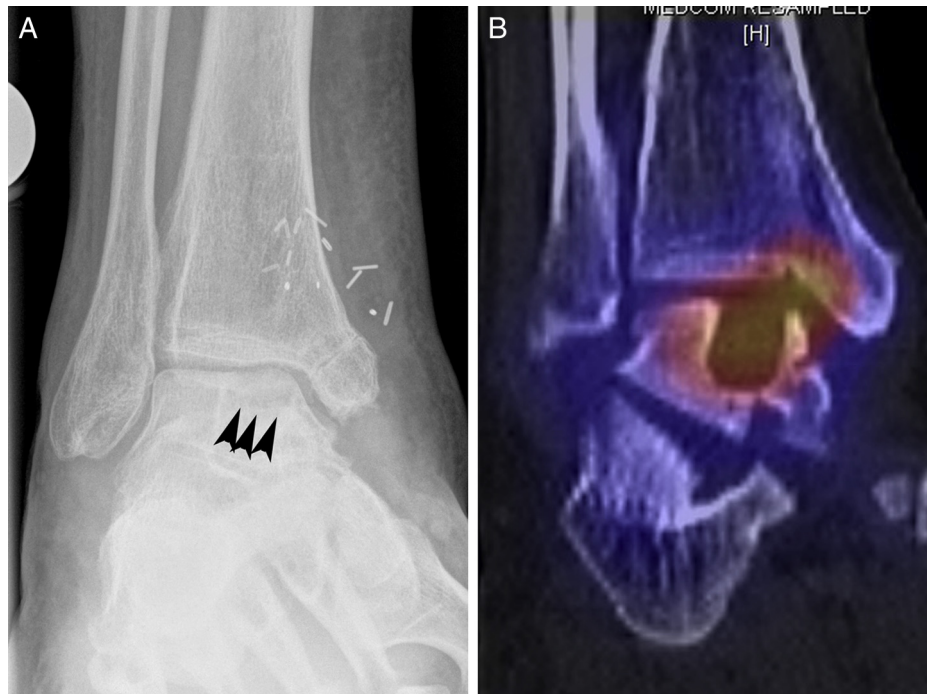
Preoperative imaging studies. The patient had a recurrent osteochondral lesion of the talus after a failed reconstruction attempt. (A) Planar radiograph (anteroposterior view) and (B) single photon emission computed tomography-computed tomography scan (coronal view) showing a large bony defect (*arrowheads*) at the medial talar edge.
